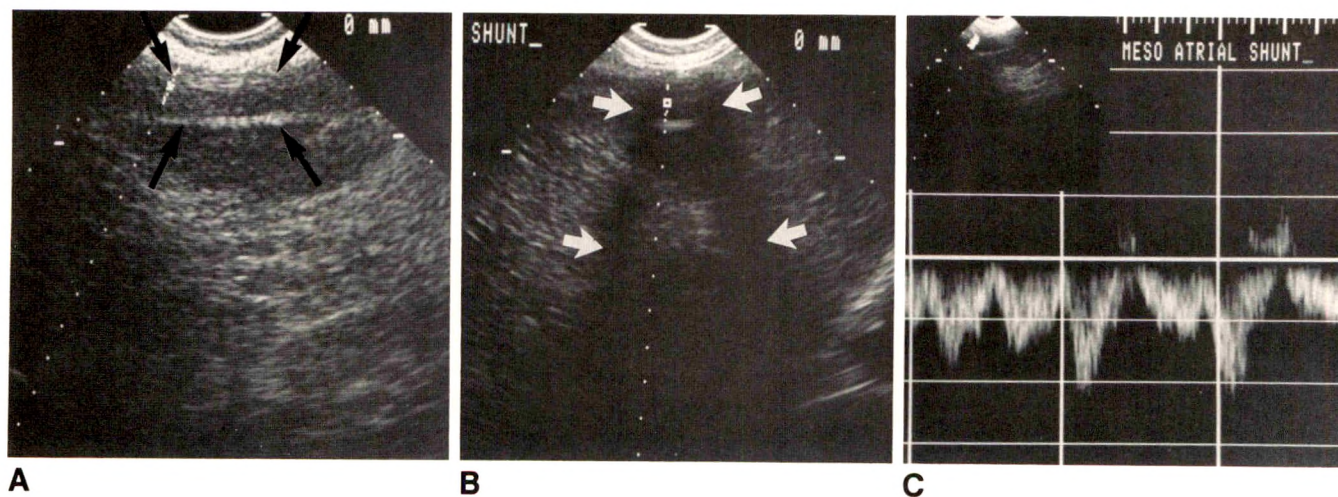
A, Longitudinal sonogram of right subcostal area shows superficial location of mesoatrial shunt (arrows).
